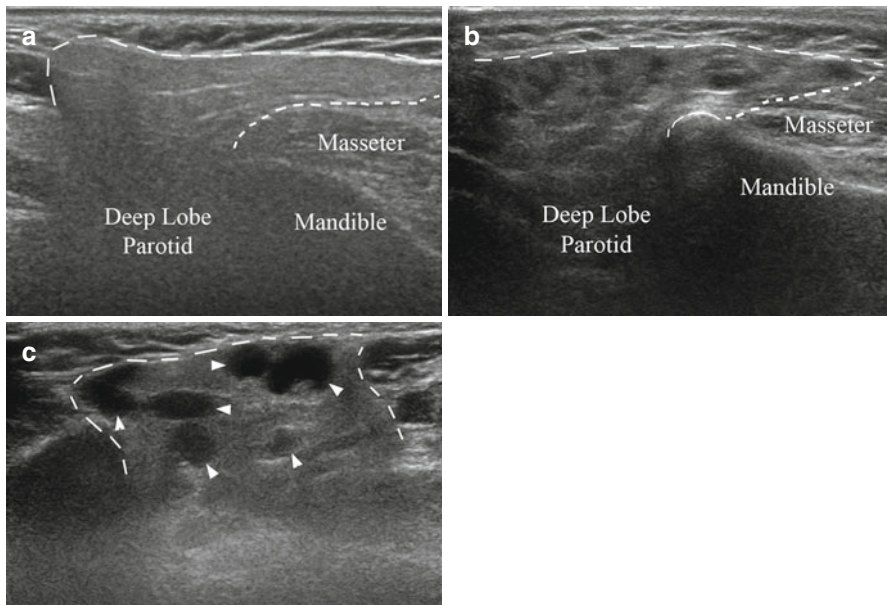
Ultrasonography of the major salivary glands. (a) demonstrates the appearance of a normal right parotid gland (anterior to the *right*, posterior to the *left* of the image). The tissue in the upper part of the image is the skin and dermal layers. The *dashed line* represents the superficial edge of the parotid gland. The shorter *dashed line* indicates the boundary of the parotid and the masseter muscle. Sound waves do not penetrate the mandible, and the white line inferior to the masseter is the buccal (lateral) corticated border of the right ascending ramus. The parotid tissue extends into the deep lobe posterior to the ascending ramus, but its full extent is not visualized. (b) demonstrates a right parotid gland at a similar position within the gland. Note the more heterogeneous appearance to the echotexture of the gland, with intermittent hypoechoic (*darker*) areas, particularly within the superficial layers in this case. This is termed a mild honeycomb appearance. (c) demonstrates a right parotid gland with more severe changes associated with Sjogren's syndrome. The distinct foci (marked by *white arrowheads*) are darker (hypoechoic) and larger
